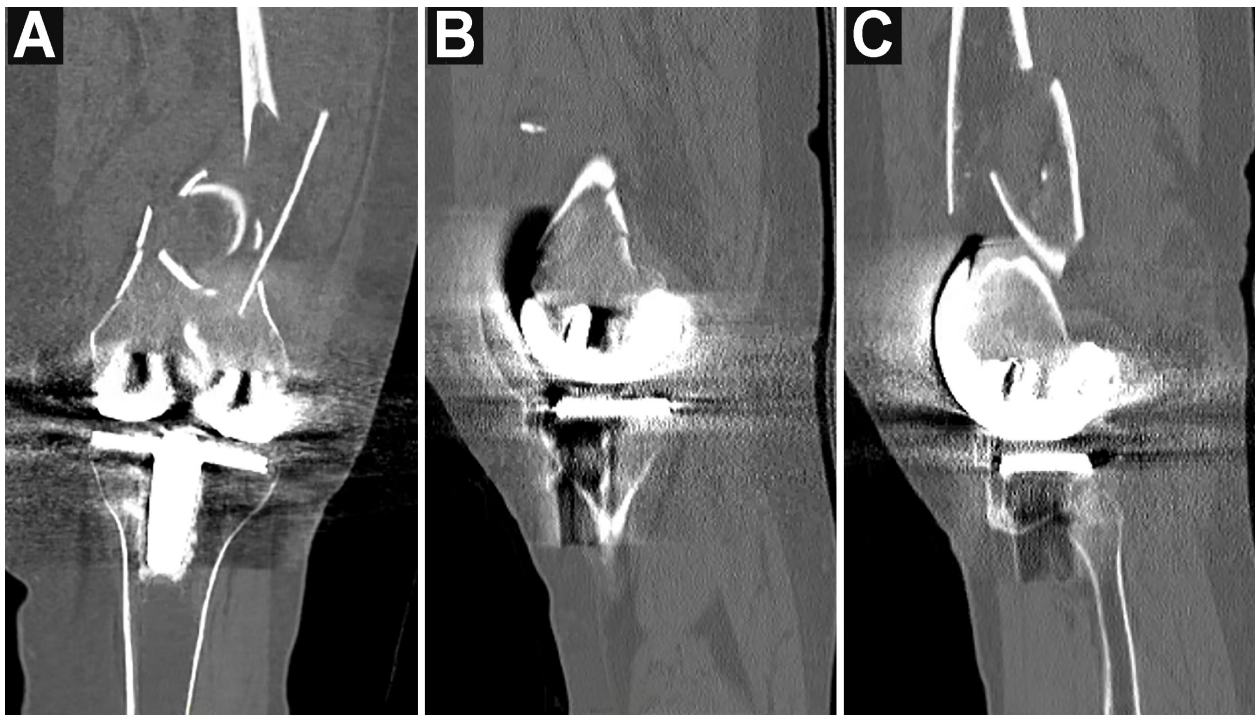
Coronal (A), sagittal medial (B), and sagittal lateral (C) CT of the left knee demonstrating comminuted distal femur periprosthetic fracture.
